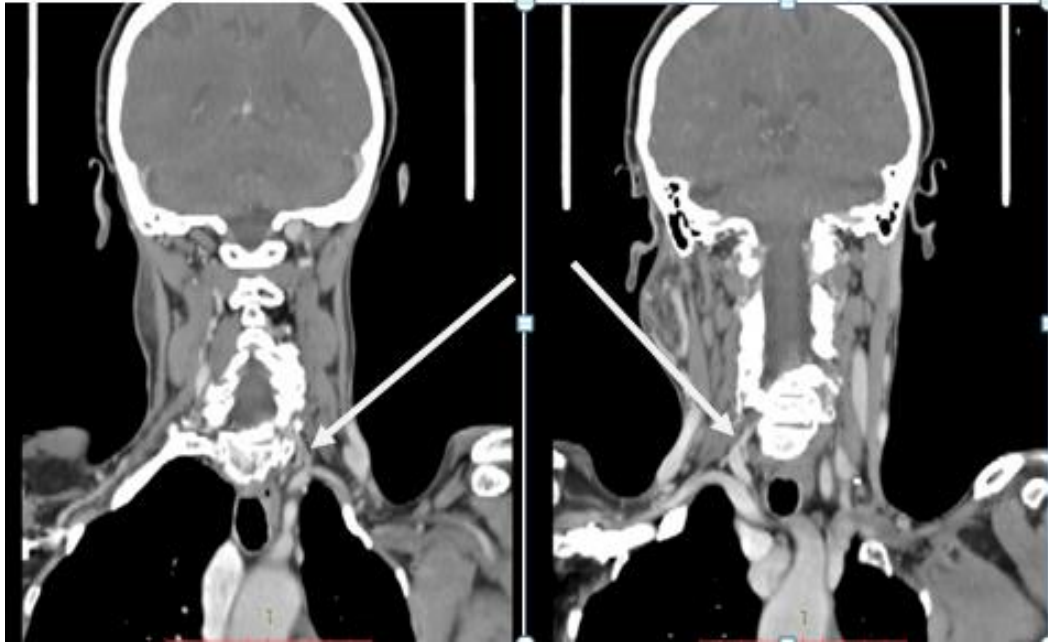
Right and left dual origin of the VA from the subclavian arteries in coronal CTA
